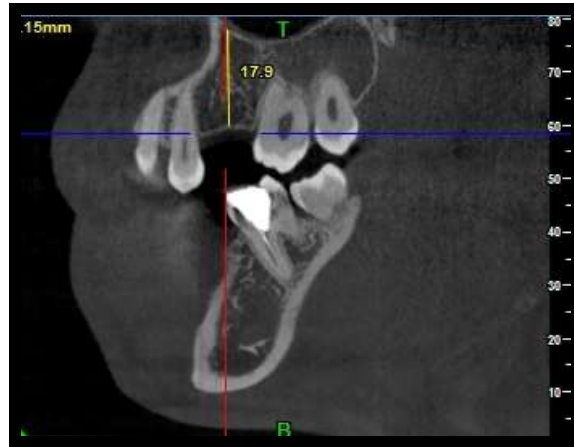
Pretreatment CBCT showing bone height of 17.9mm
